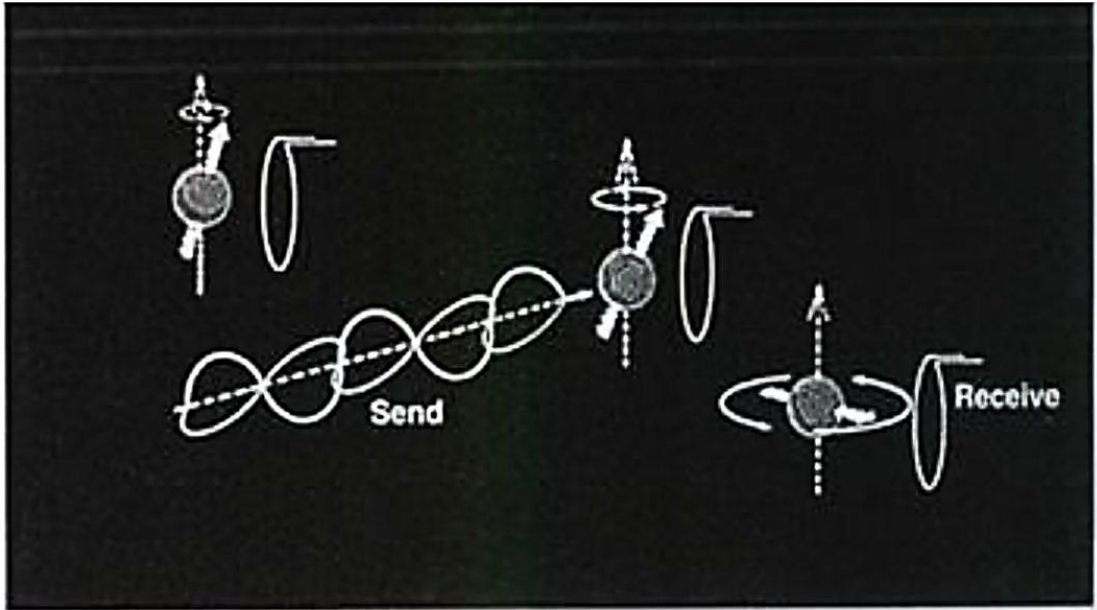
MRI signal generation and receiver coil sending electrical signal to computer. (Bushong, 2005)
